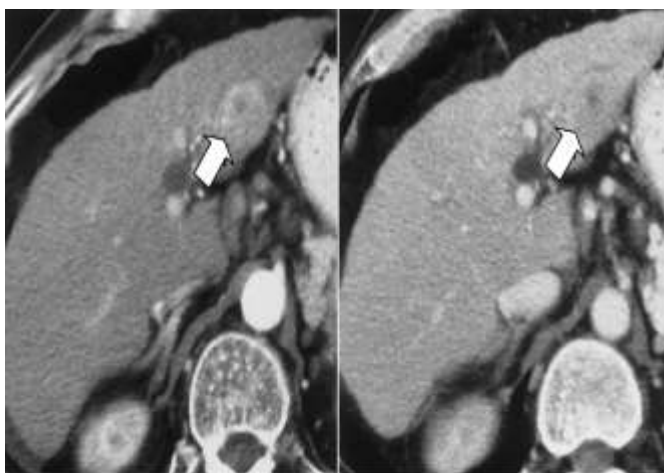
Homogenous enhancement of HCC: 47 year male patient Small HCC, with a typical finding and washout. Transverse hepatic arterial phase CT image of midliver. The mass (arrow)
